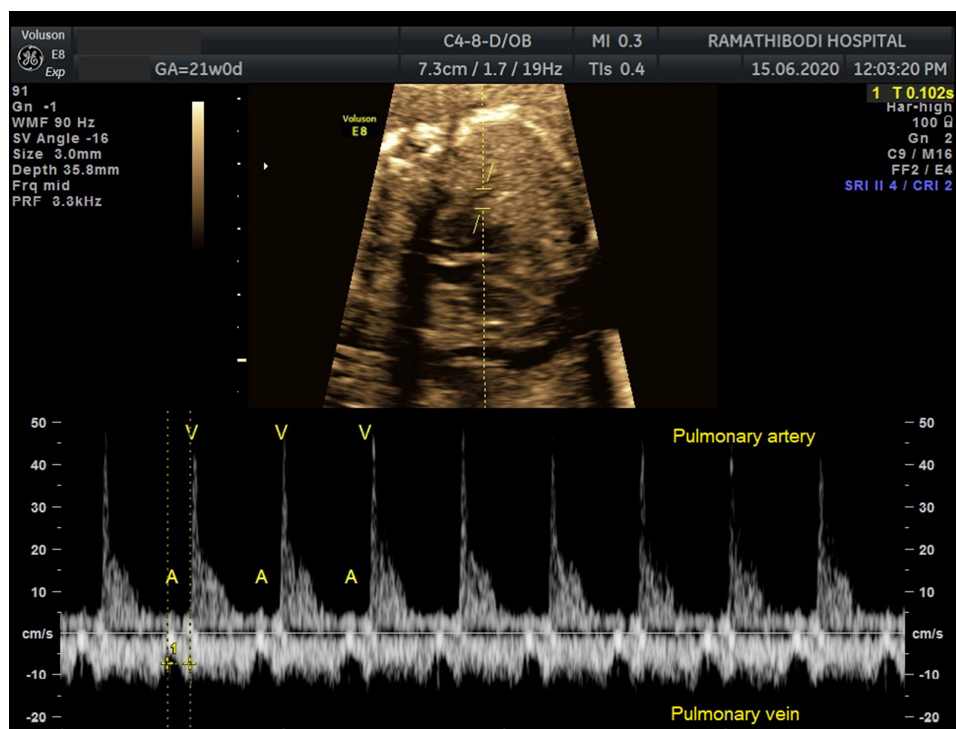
Pulsed wave Doppler image of pulmonary artery–pulmonary vein (PA–PV) view obtained from four-chamber view, mechanical PR interval was measured between onset of pulmonary vein atrial wave and onset of pulmonary artery ejection flow.
